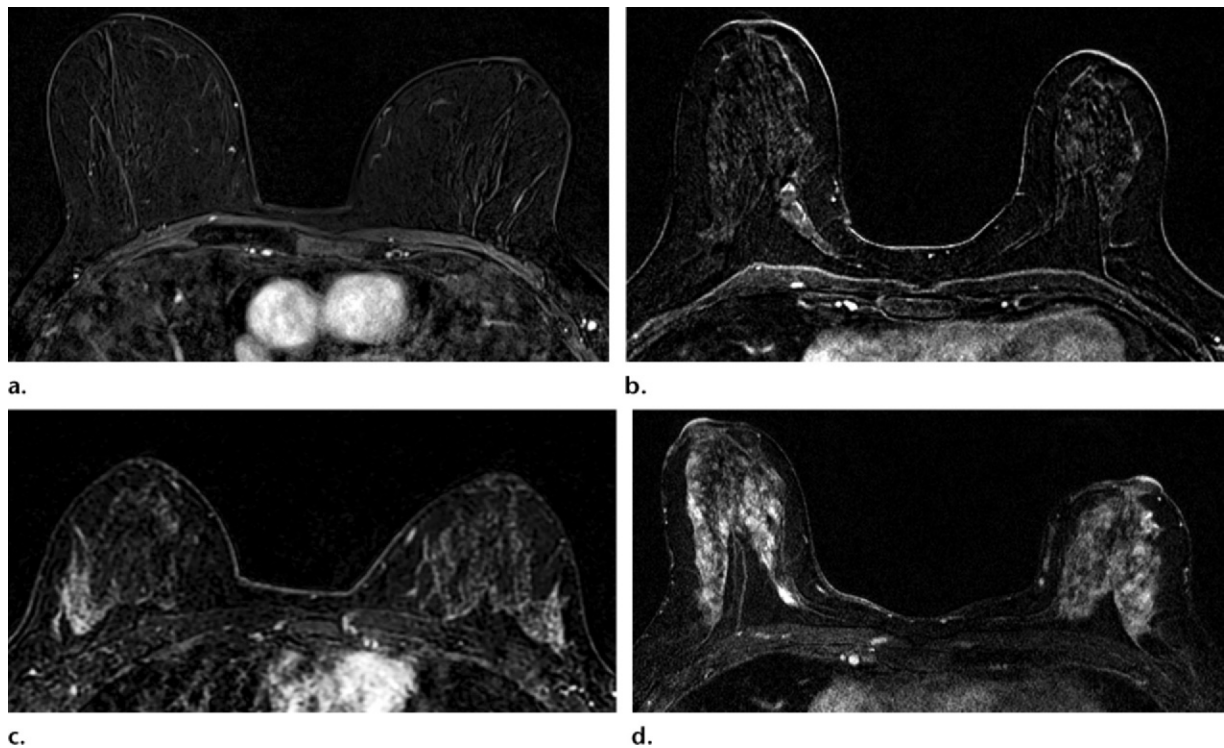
Axial contrast-enhanced T1-weighted fat-suppressed MR subtraction images in four different women show varying degrees of BPE: minimal BPE (<25% glandular enhancement) (a), mild BPE (25%–50% glandular enhancement) (b), moderate BPE (50%–75% glandular enhancement) (c), and marked BPE (>75% glandular enhancement) (d).
